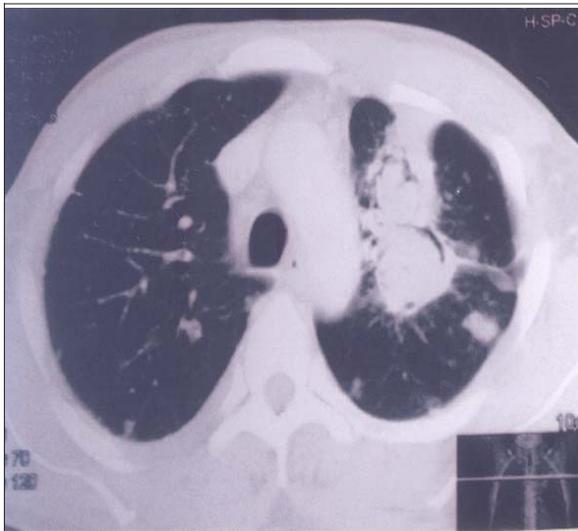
CT chest showing a cavity with an aspergilloma and parenchymal lesion in left upper lobe.
